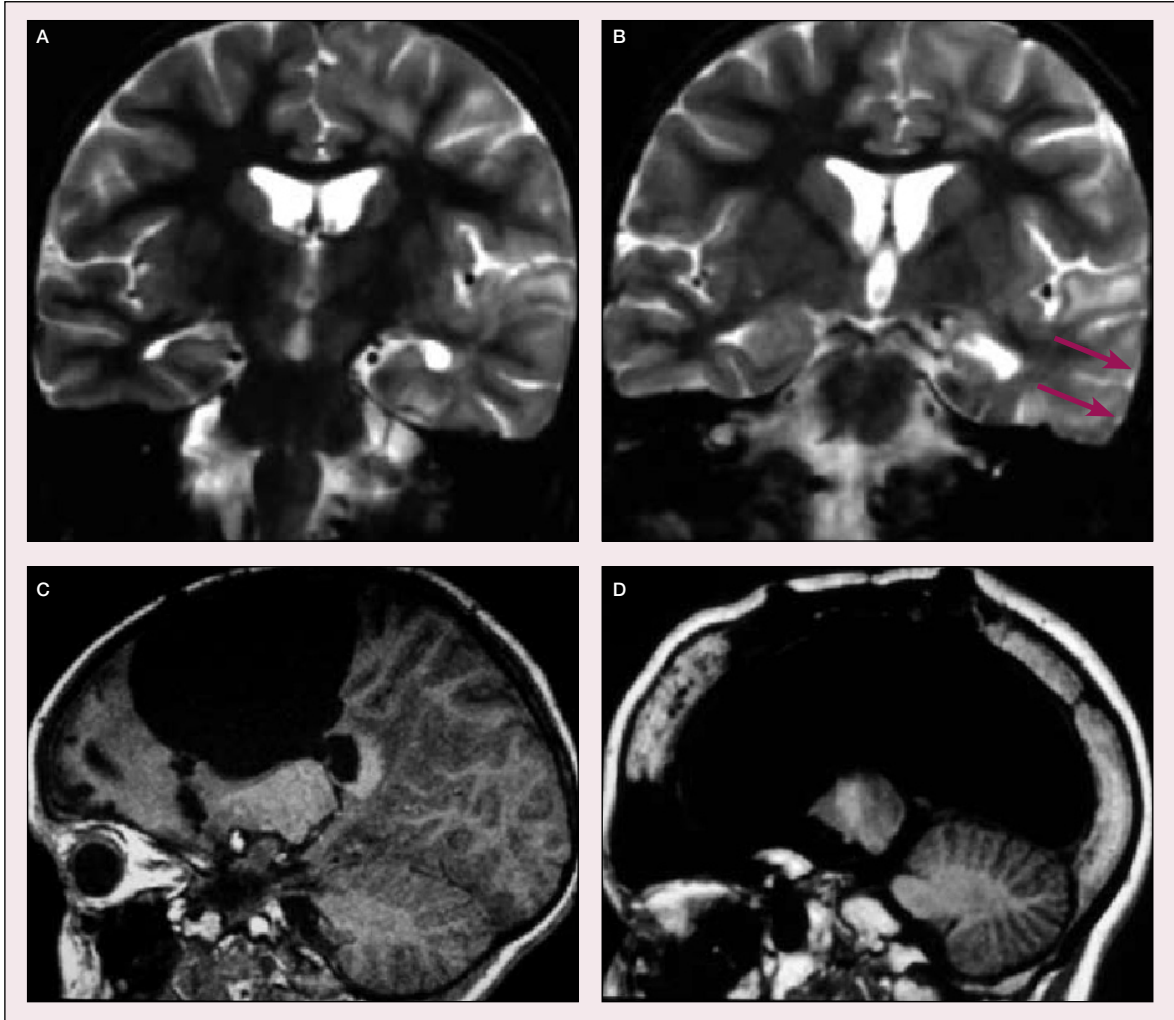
Progression of the disease in brain MRI before (A,B) and after (C,D) functional hemispherectomy. The images on the right (B,D) were obtained 5 months after those on the left (A,C).
